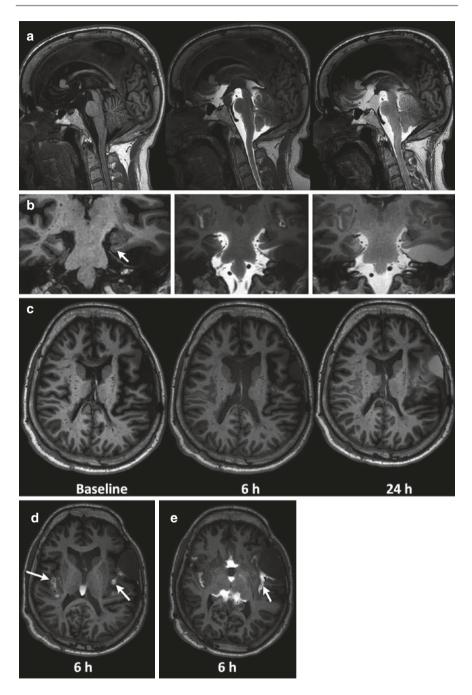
gMRI from a 42-old-man treated with a ventriculo-peritoneal shunt for 36 years since childhood (age 6 years) due to communicating hydrocephalus of unknown cause and a left temporal arachnoid cyst. Prior to gMRI, he had a history of about 2 years with symptoms characterized by headache, dizziness, fatigue, and cognitive impairment. He was after ICP monitoring diagnosed with overdrainage and therefore underwent a shunt revision. (a) Sagittal T1 weighted MRI shows contrast agent serving as CSF tracer, enriching the subarachnoid and ventricular spaces. No enrichment was seen within the CSF over the convexities at any time point. (b) The left parahippocampal gyrus was compressed by the cyst and dislocated upward (arrow). Signs of delayed CSF tracer (contrast agent) clearance was found in the left cortex as it revealed increased amounts of remaining CSF tracer at 6 and 24 h (T1 signal unit ratio after 6 h had increased 116% vs. 78% at the left vs. right side, and had after 24 h increased 79% vs. 65% at the left vs. right side. (c) At 6 h, the ventricular size was markedly increased despite no alterations in the cortical subarachnoid spaces, which suggests reduction in parenchymal volume, and highlights the dynamic nature of the brain volume. The altered ventricular size cannot be caused by respiration (or Valsalva) since the scan lasts 5–6 min. No movement artifacts can be seen. (d) The perivascular contrast enrichment surrounding branches of the middle cerebral artery within the Sylvian fissure was evident (arrows) and was not influenced by the left arachnoid cyst. (e) Neither the contrast enrichment within the Sylvian fissure (arrow) was affected by the arachnoid cyst. Hence, in this individual, the arachnoid cyst appeared not to obstruct CSF flow within nearby subarachnoid spaces of the Sylvian fissure
